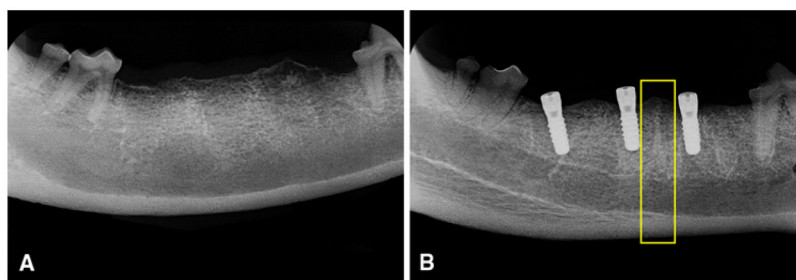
Radiographs of the control side of the mandible. a After extraction of the teeth. b After placement of dental implants. *Yellow rectangle* indicates the VOI of the 3D analysis between two implants
